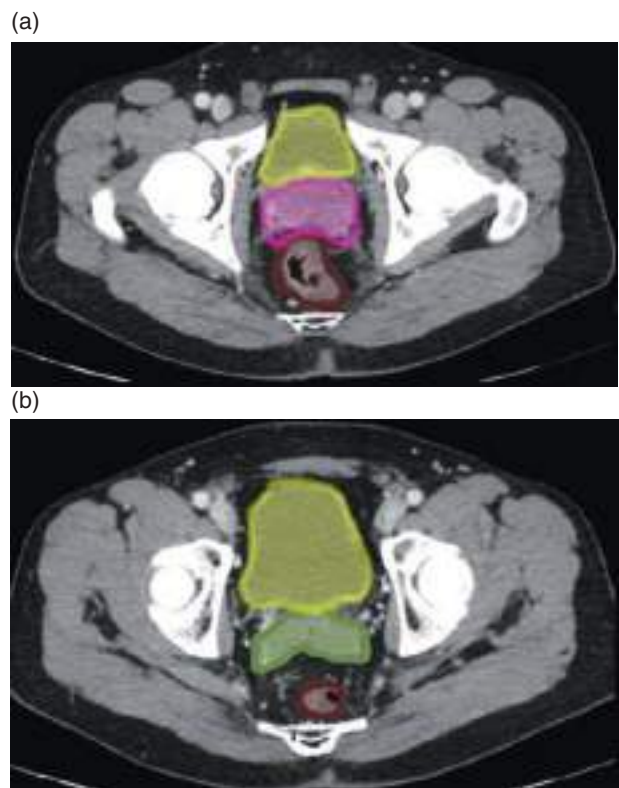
(a, b) Axial contrast-enhanced CT image (portal venous phase). (c) Sagittal contrast-enhanced MPR CT image (portal venous phase).
